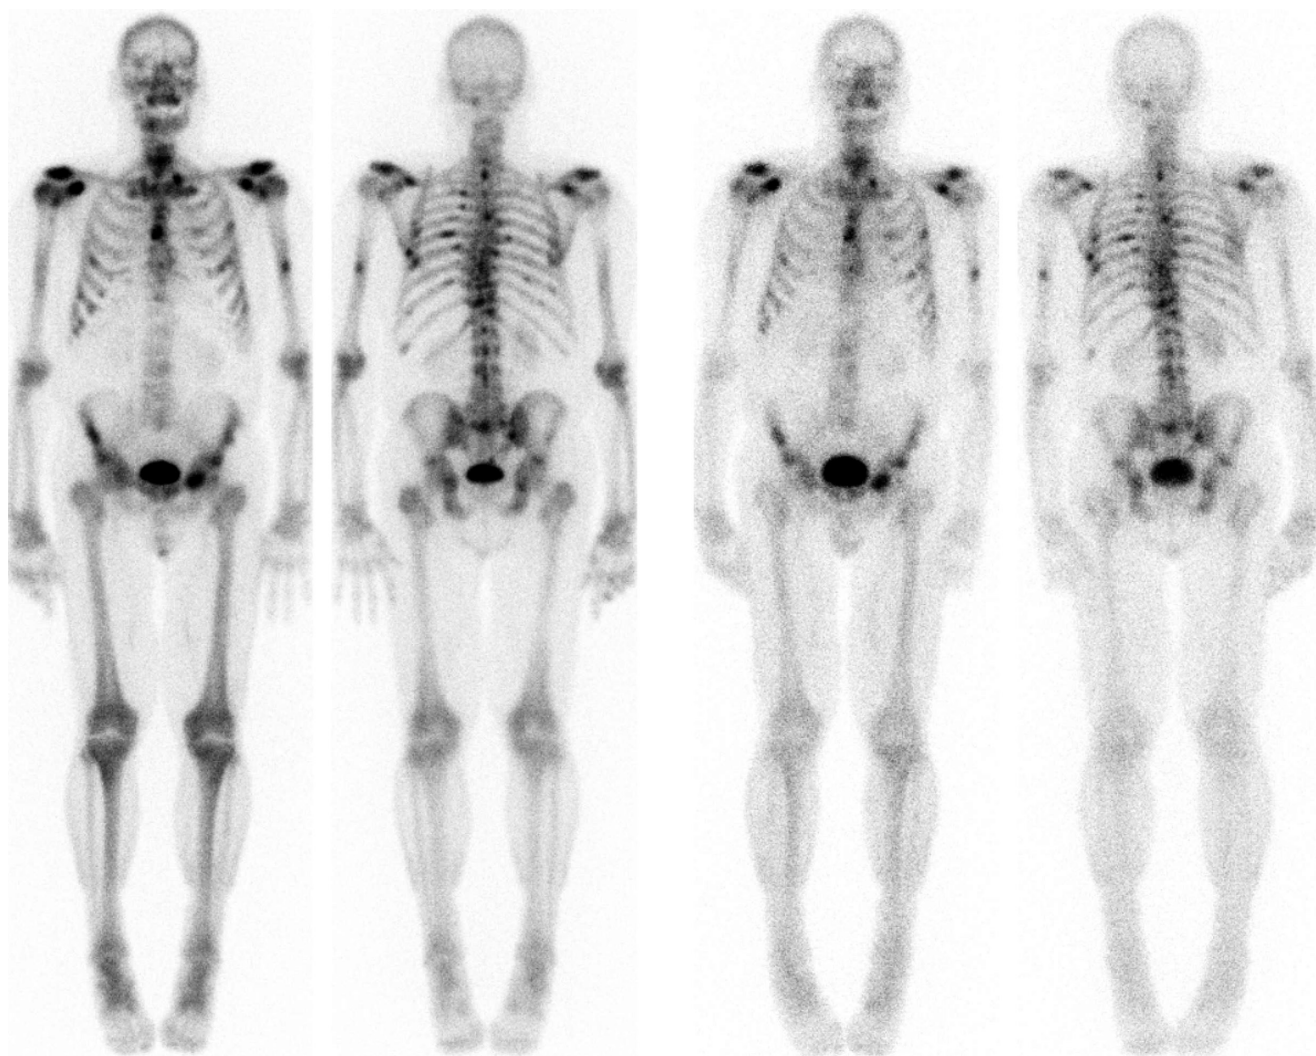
Example of imaging and therapy with bone-seeking radiopharmaceuticals. A 79-year-old man with castration-resistant prostate cancer with lymph node and skeletal metastases. The left panel shows anterior and posterior views of diagnostic ^{99m}Tc-HDP scintigraphy, demonstrating multiple skeletal metastases in left humerus, sternum, ribs, multiple vertebrae, and pelvis. The right panel shows anterior and posterior views of post-therapy scintigraphy after administration of ¹⁵³Sm-EDTMP therapy, demonstrating similar biodistribution. ¹⁵³Sm-EDTMP, samarium-153 ethylene diamine tetra methylene phosphonate; ^{99m}Tc-HDP, technetium-99m-hydroxymethylene diphosphonate.
